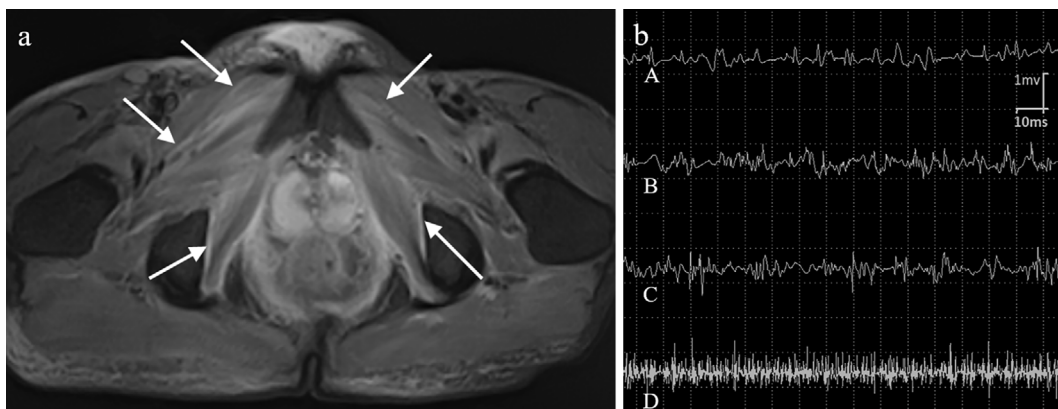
a: Magnetic resonance imaging of skeletal muscles reveal abnormal hyper intensity areas (arrows), b: Electromyography of biceps brachii (A), deltoid (B), and external carpi radialis (C, D), all of which display low amplitudes.
